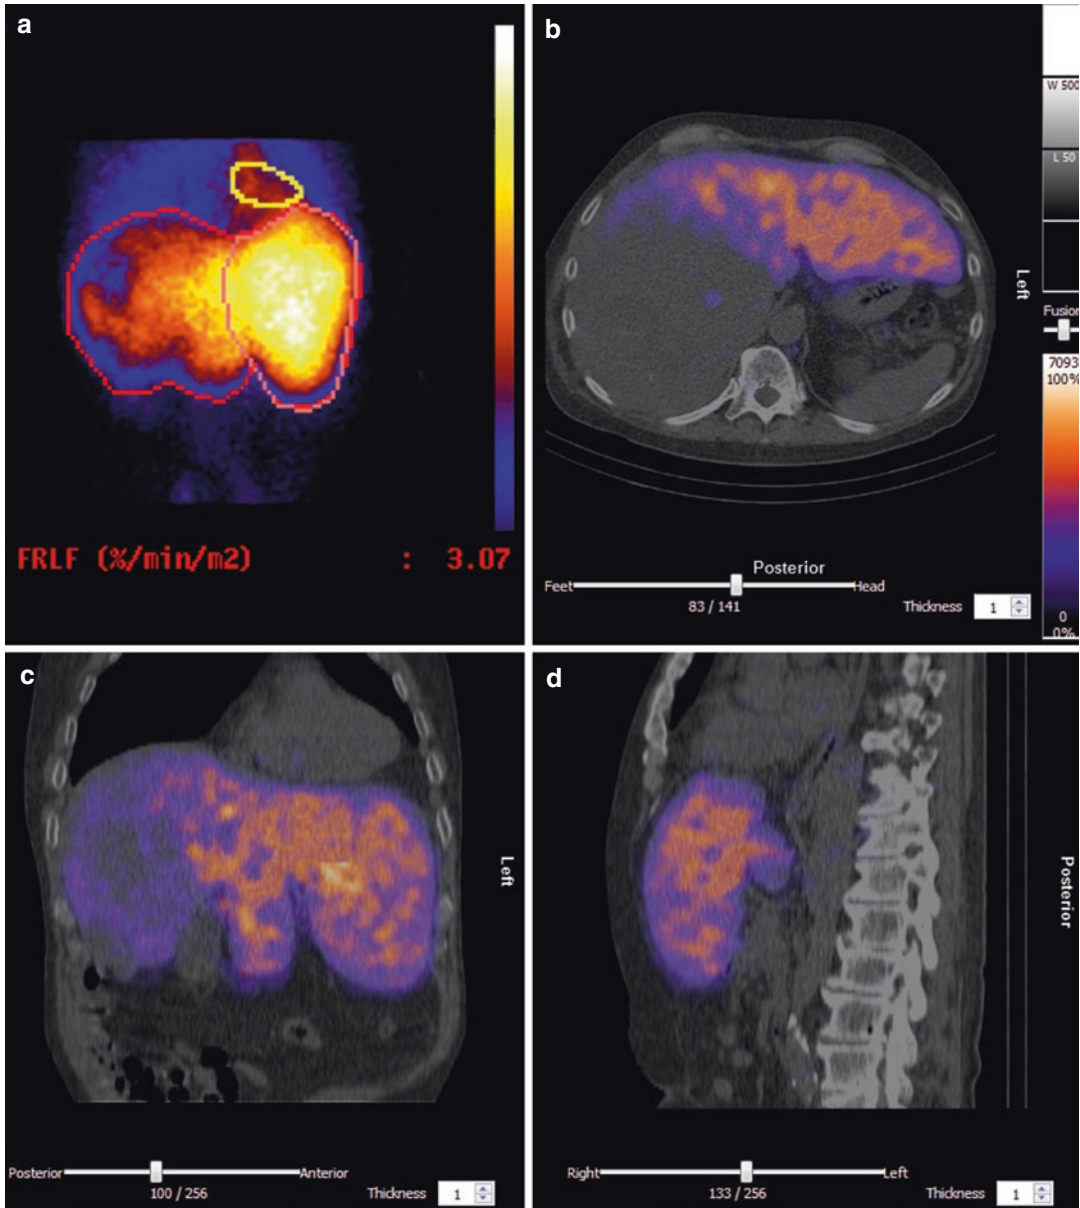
Preoperative hepatobiliary scintigraphy in a 56-year-old male patient with a large resectable HCC in the right liver segments. Summed dynamic scintigraphy (a) showing hypertrophy and function of the left liver segments. The future remnant liver function was determined
